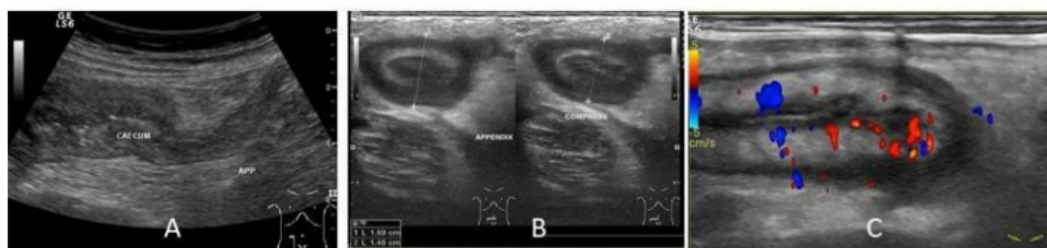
Ultrasound normal appendix at the terminal of caecum (A). Uncompressed appendix in acute appendicitis (B). Appendix in longitudinal view with Doppler ultrasound, thickening of appendix wall in acute appendicitis (C).
